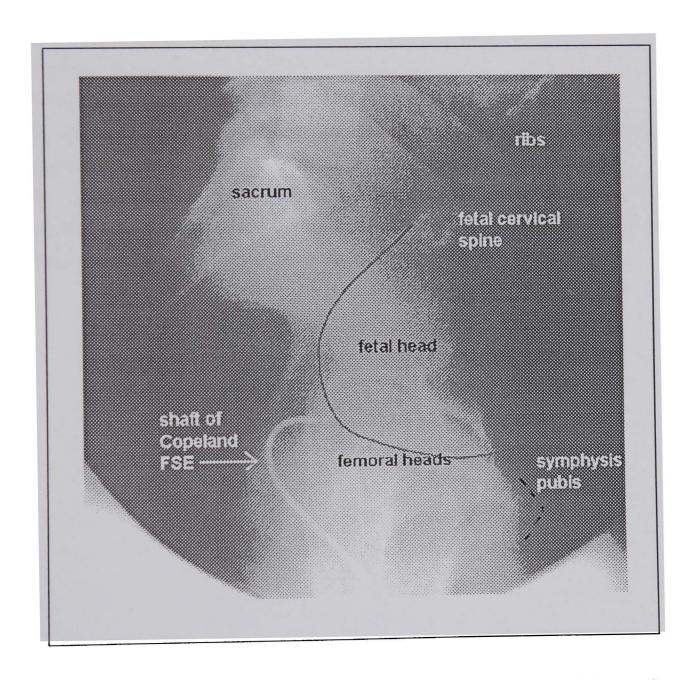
X-ray showing the attachment of the Copeland electrode.
